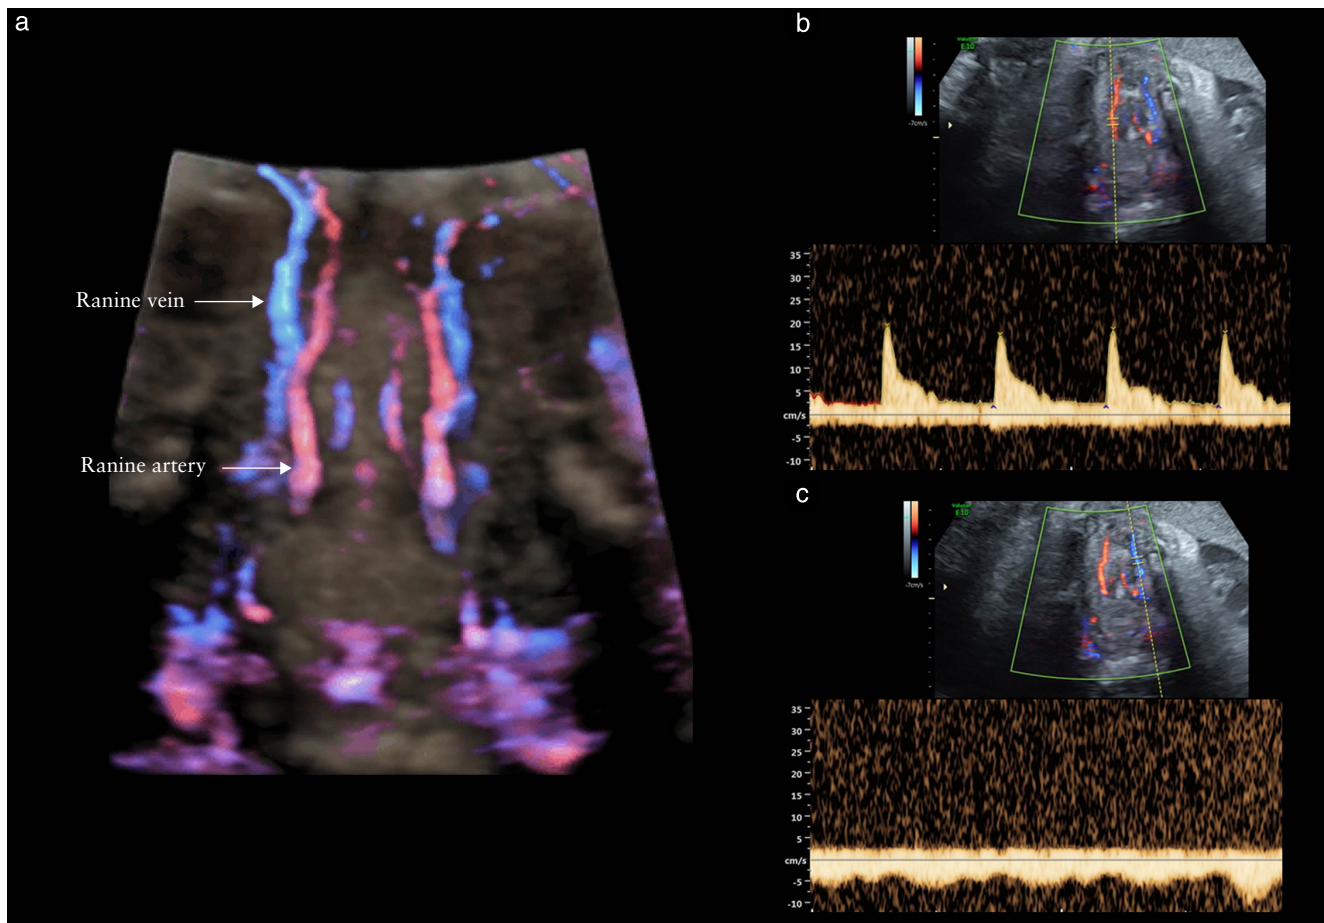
Cross-sectional Doppler ultrasound images of fetal tongue at 34 weeks of gestation, showing deep lingual (ranine) arteries and veins. (a) Image obtained using RM6C volumetric probe and 3D HD-Flow™. (b,c) Spectral Doppler displaying deep lingual artery (b) and deep lingual vein (c) waveforms.
